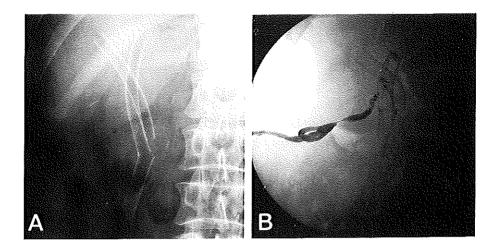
Patient with a type III hilar stricture caused by cholangiocarcinoma. (a) Radiograph obtained six weeks after placement of three stents in a Y configuration reveals additional shortening of the stents with poor alignment. No signs or symptoms of reobstruction were present.
